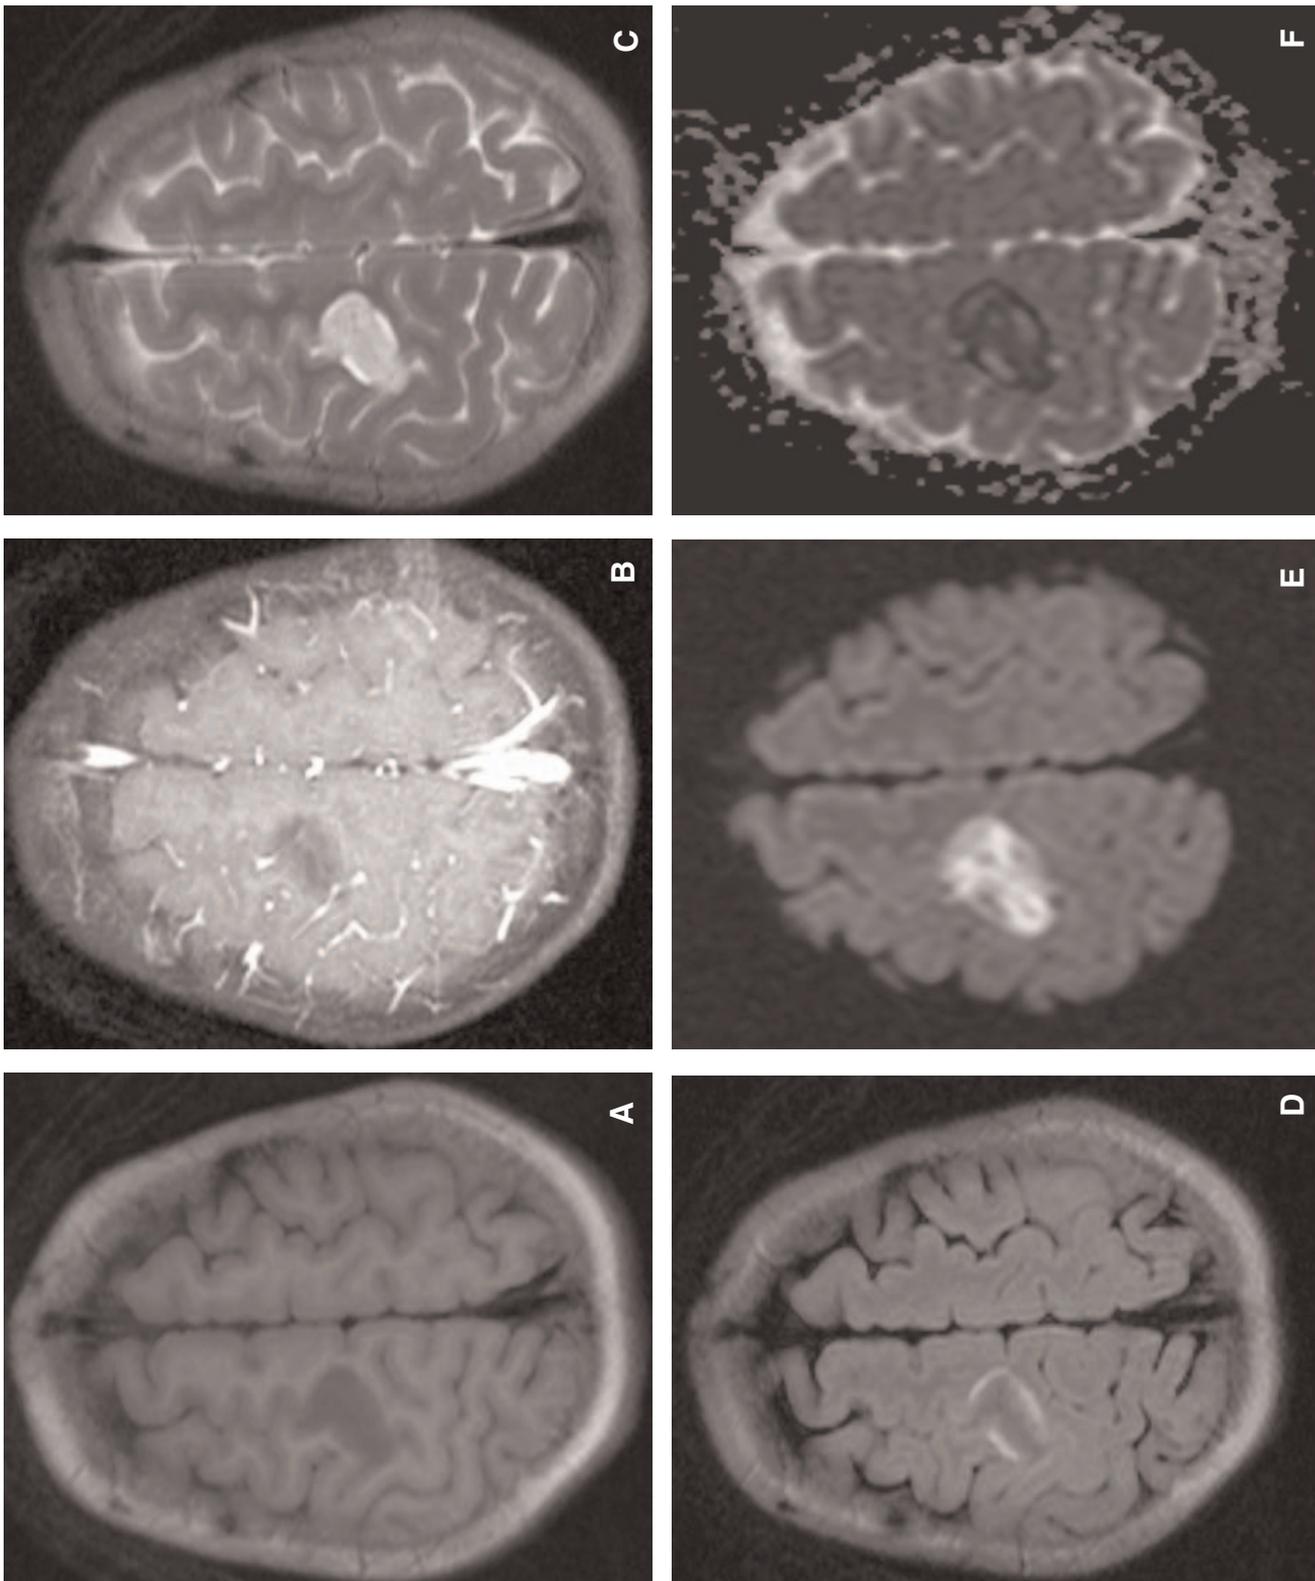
Magnetic resonance imaging of the right frontal lesion 24 hours after symptom onset. Axial T1 weighted images without (A) and with (B) gadolinium show a discrete, gyriform enhancing lesion in the right frontal lobe. The lesion is hyperintense on axial T2W (C) but shows minimal increased signal on the FLAIR images (D). The lesion is hypointense on DWI (B1000 series) (E) and hypointense on the ADC map (F), in keeping with restricted diffusion.
